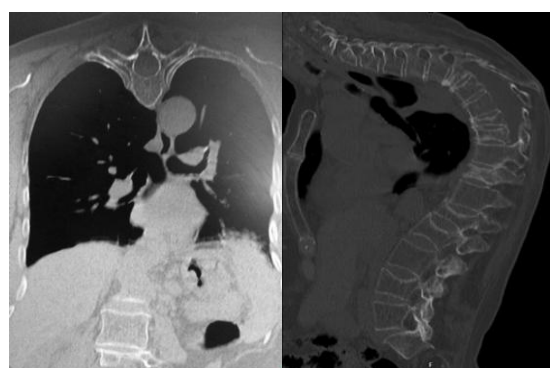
a and b. CT coronal (a) and sagittal (b) plane shows severe kyphotic deformity of the thoracic spine with a significant increase of the space between the sternum and the column.
